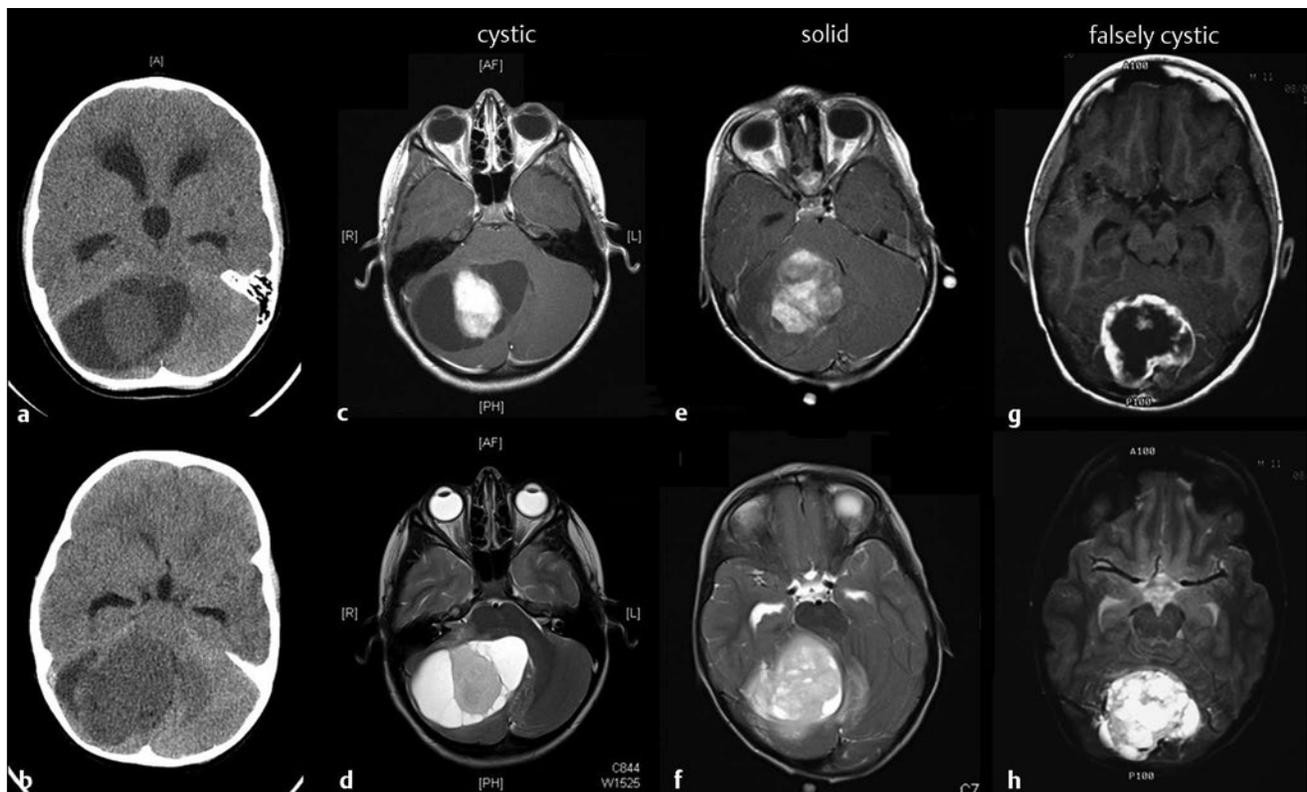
Radiologic appearance of cerebellar pilocytic astrocytoma. Nonenhanced axial computed tomography shows either a hypo- or isodense nodule surrounded by signal, consistent with a fluid-filled cavity (a), or a slightly hypodense and heterogeneous mass in the case of a solid tumor (b). T1-weighted magnetic resonance imaging after the intravenous administration of gadolinium differentiates among “classic” cystic (c), solid (e), and falsely cystic (g) tumors. Neoplastic tissue enhances briskly upon contrast injection. In T2-weighted images, the solid component of the tumor (d,f,h) appears hyperintense to normal brain, a characteristic peculiar to pilocytic astrocytomas.
